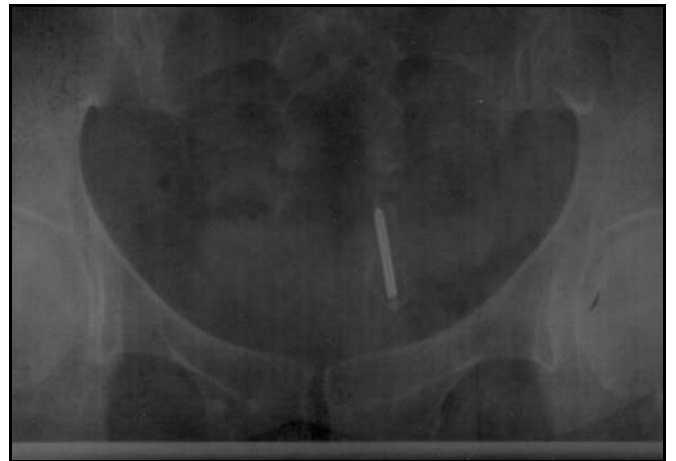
X-Ray demonstrating IUD in the pelvis.
